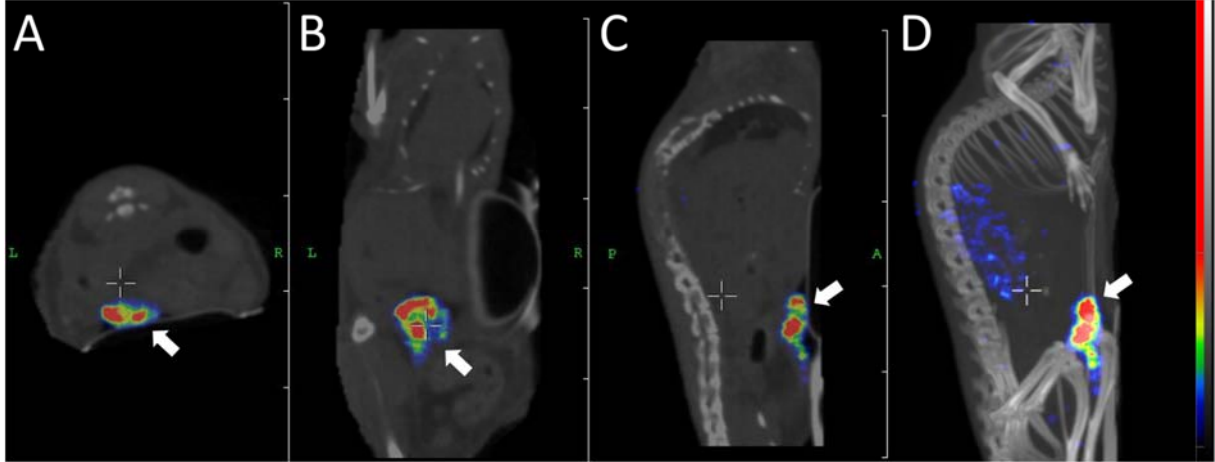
Transversal (A), coronal (B), sagittal (C) nanoSPECT/CT images and maximum intensity projection (D) obtained 30 h after injection of pretargeted ^{177}Lu -HP2. Tumor (indicated by arrow) was located on the abdomen.
